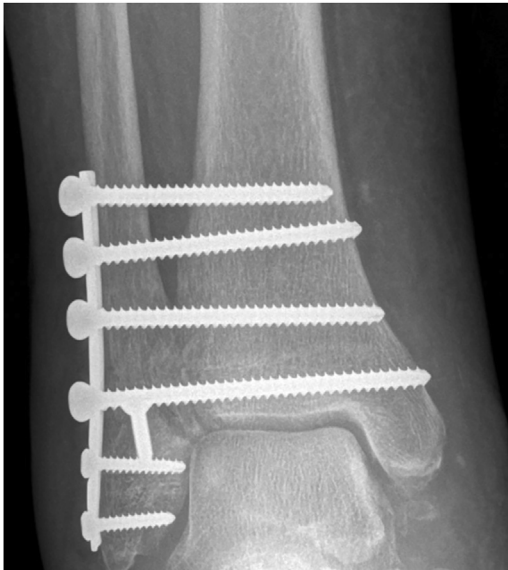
Six-week postoperative radiographs in the same patient. The syndesmosis screw ladder helped to maintain an intact mortise despite the patient walking in the cast.
